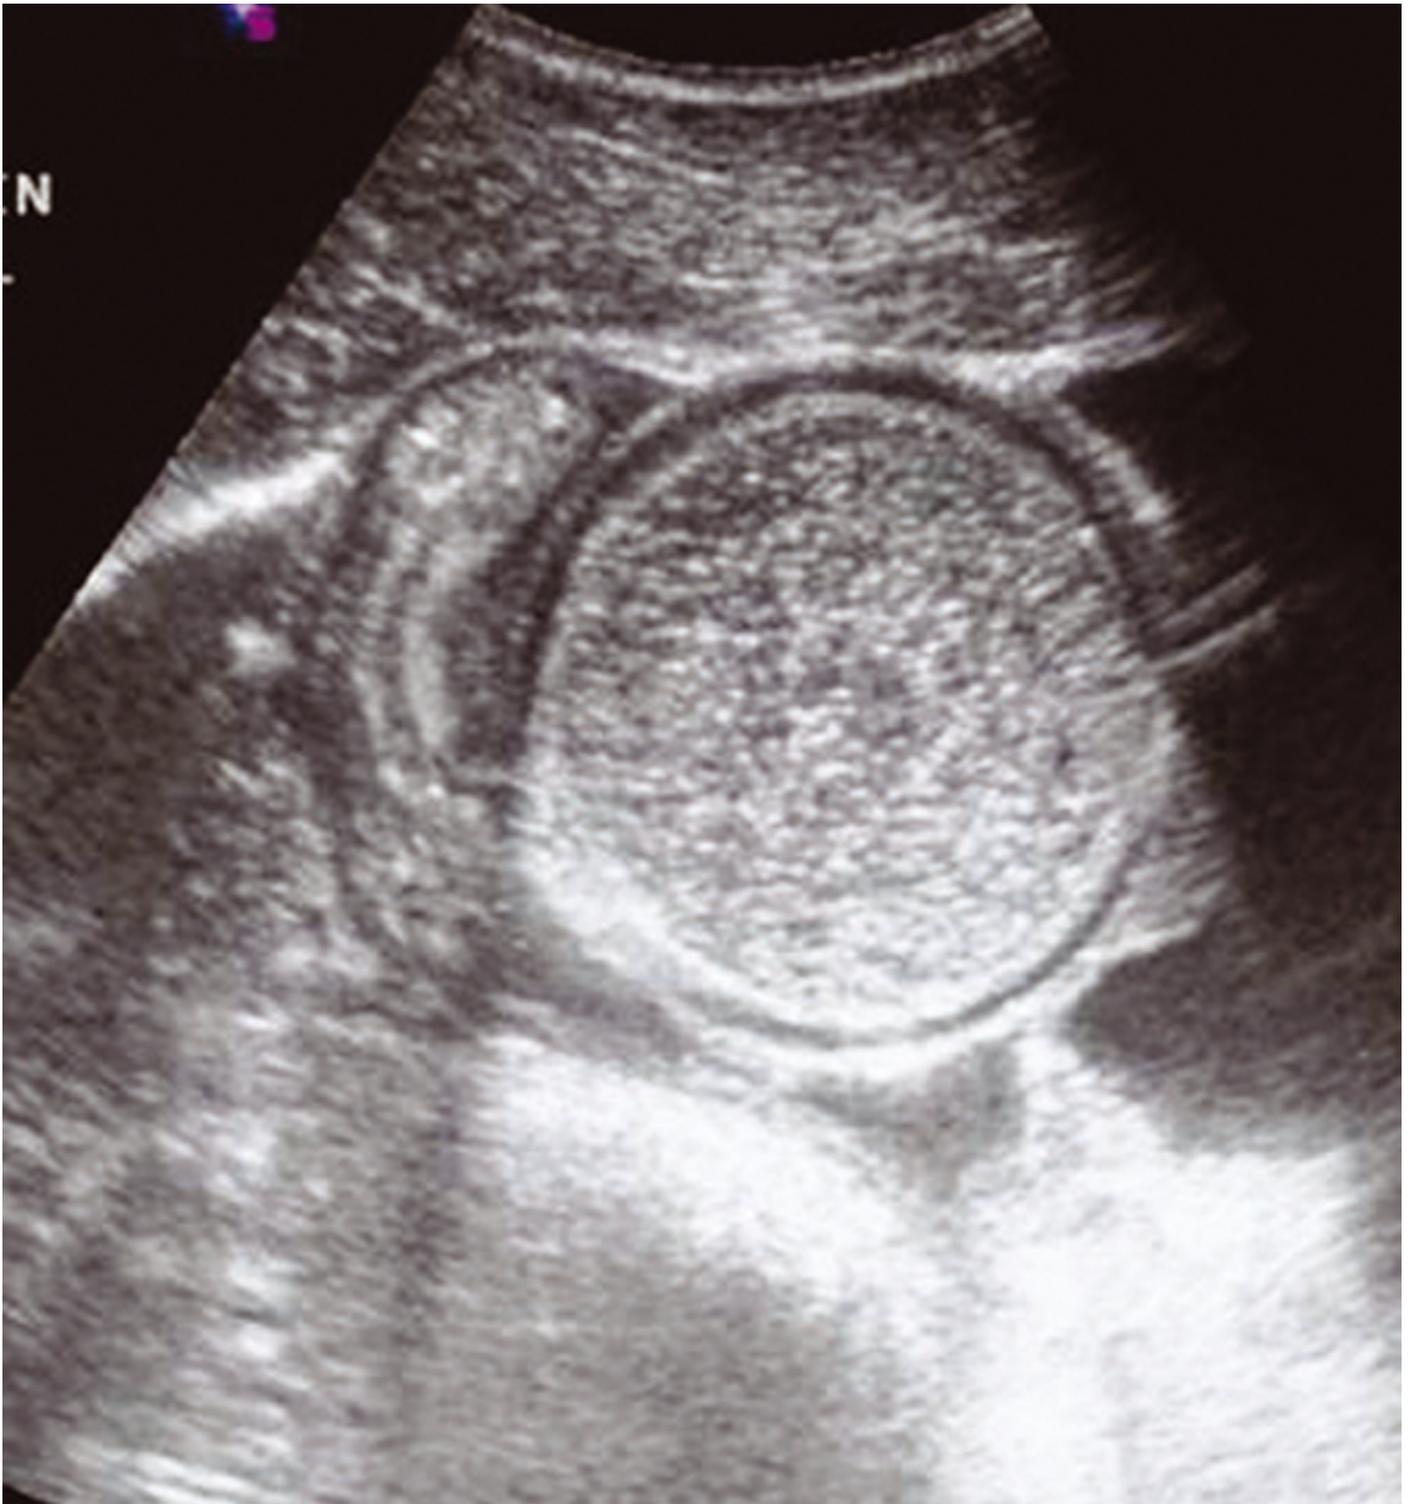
In the case study, abdominal ultrasonography revealed a distended, poorly motile loop of small intestine with a thickened, oedematous wall.
